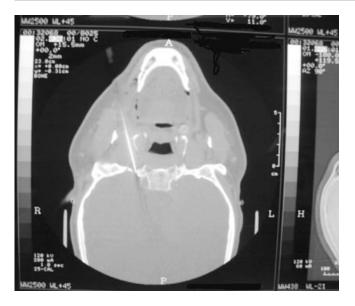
Computed tomography-guided placement of the needle through the foramen ovale.
